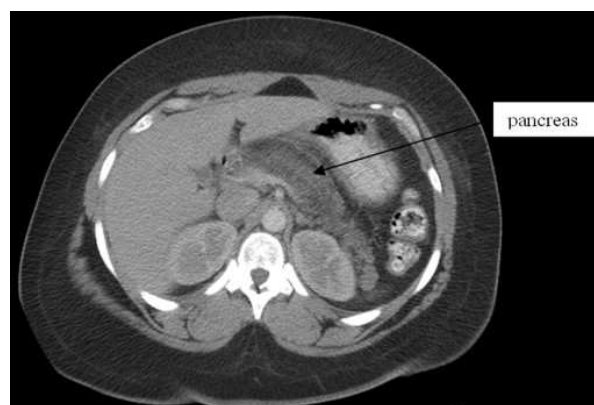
CT scan of the abdomen with contrast (Case #2).
